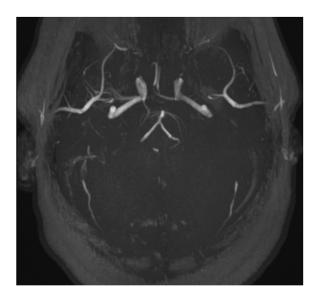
MRI image in TOF sequence showing bilateral occlusion of the posterior cerebral arteries.
